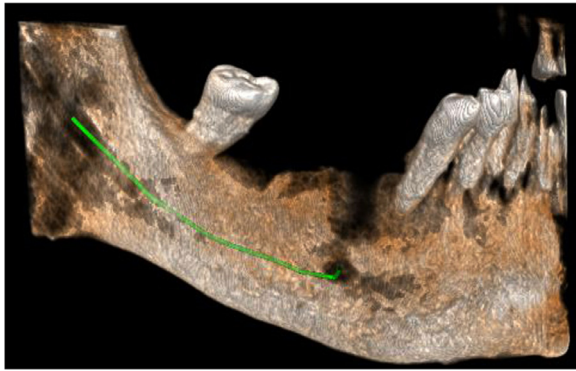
3-Dimensional computed tomographic scan showing area of necrotic bone.
